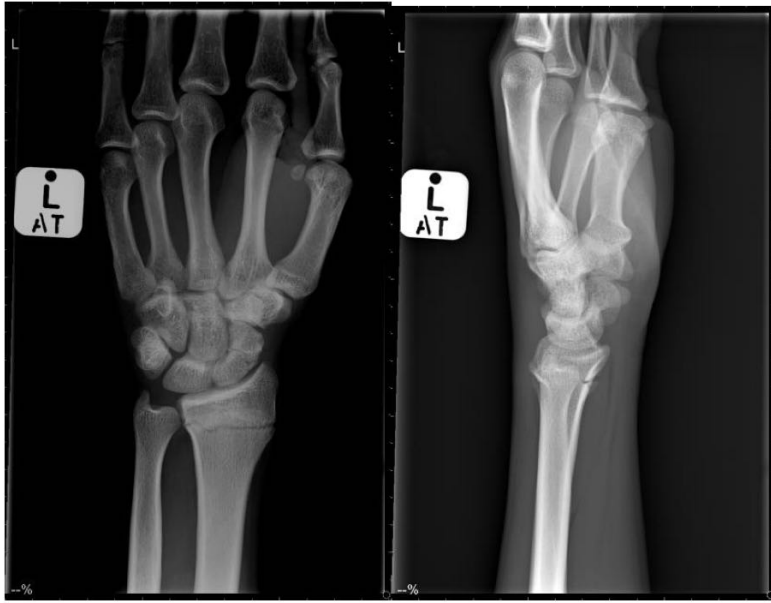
X-rays showing an undisplaced ipsilateral distal radius and scaphoid fractures
